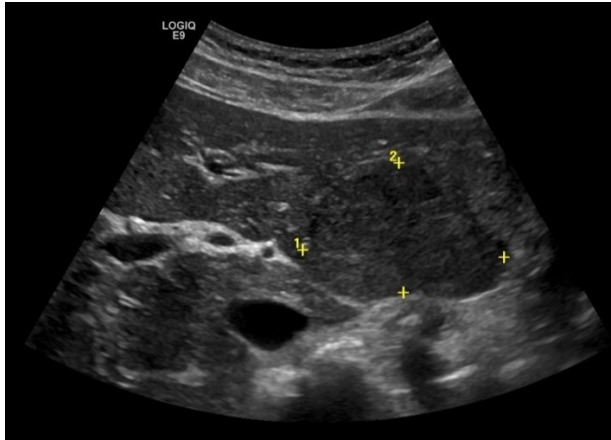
a.33. Isoechoic lesion in the left liver lobe (markers), deforming the liver outline, CEUS and MRI - HCA
